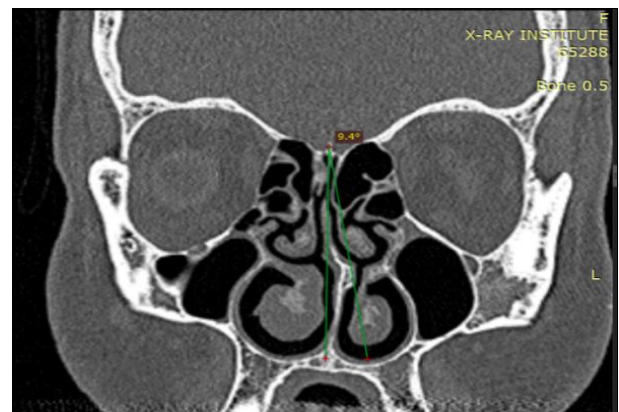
coronal PNS CT scan of 25 years old female referred for rhinoplasty showing type II NSDA measured 9.4° with C-shape left side deviation and left septal spur, hypertrophy of the right IT, clear both maxillary and ethmoid sinuses
